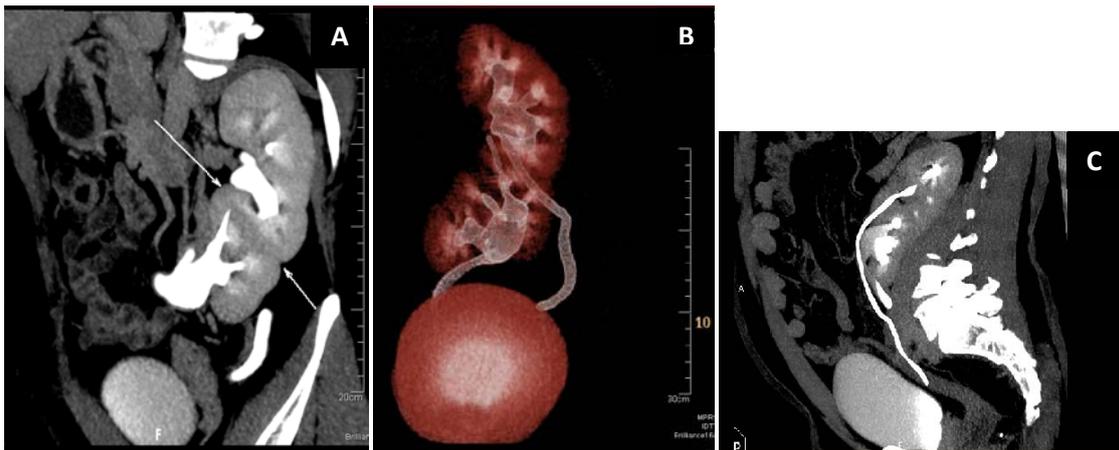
Left-right ERC without fusion in a man of 45 years. (A) MPR and coronal (B) CT volume. Note the change in the position and rotation of both kidneys, as well as large dilated ureter RE.
